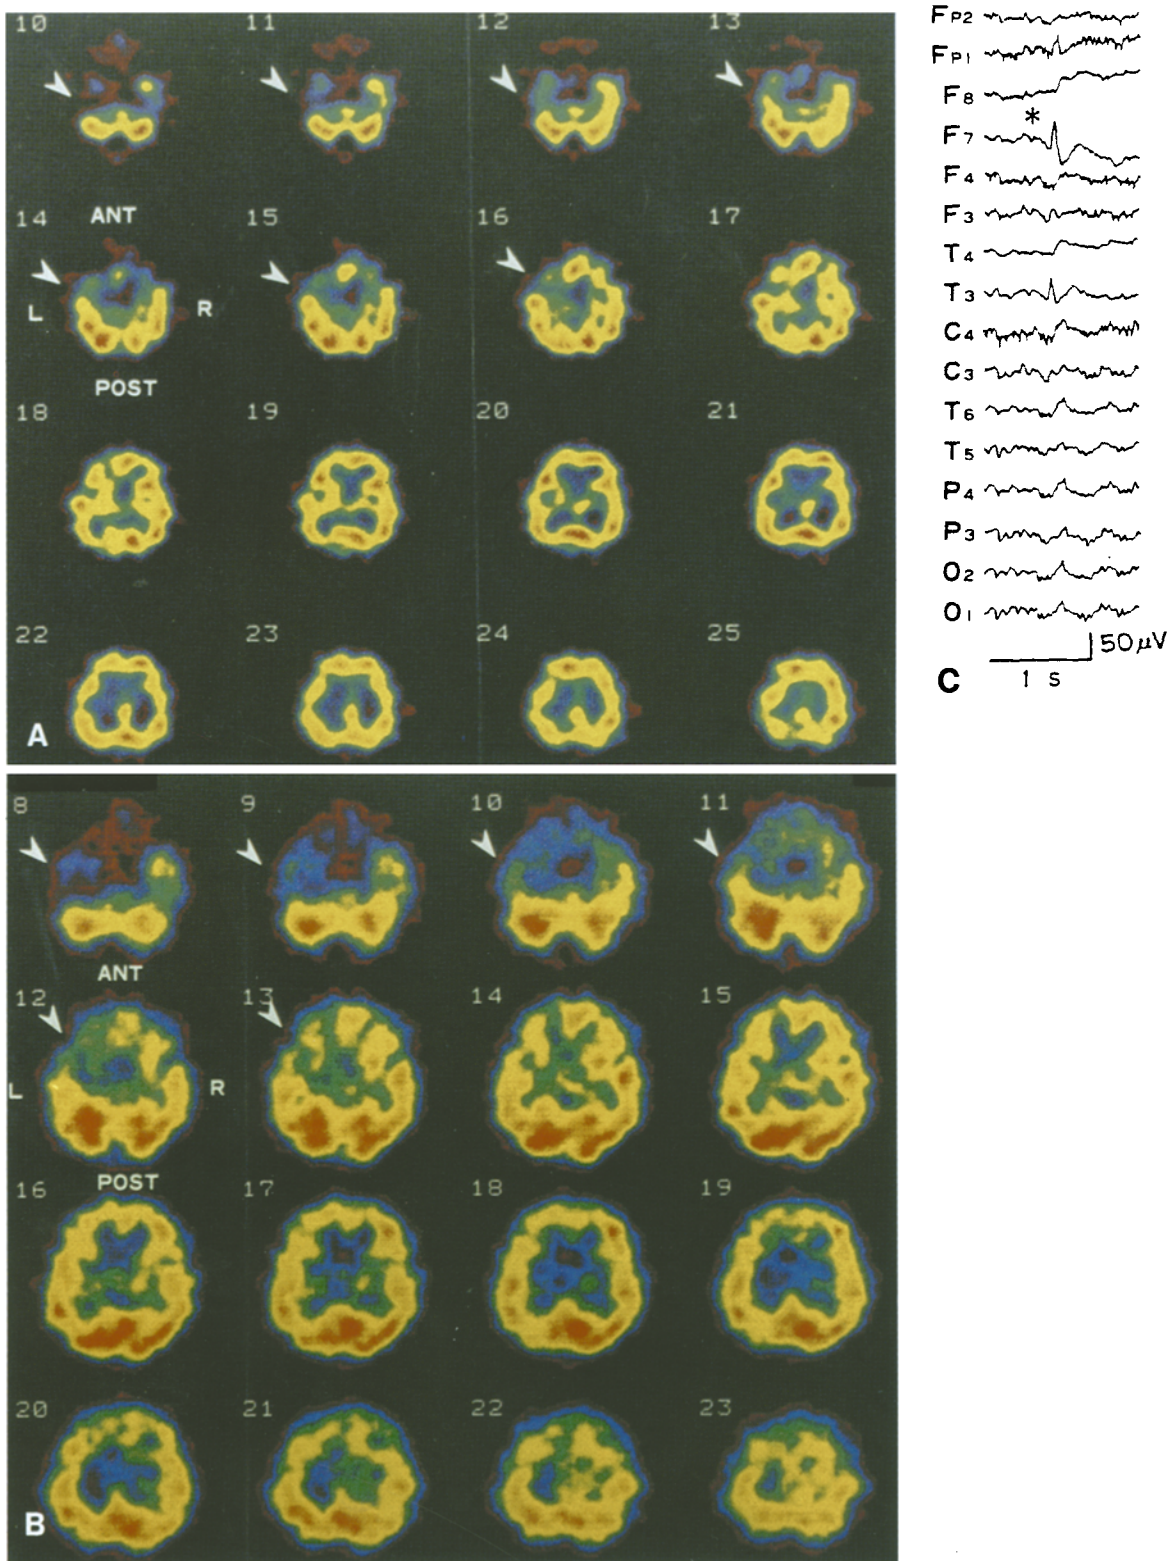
Good correspondence between regional SPECT abnormalities and epileptic EEG focus. Data from case 5 in Table 1 are presented. The upper and lower SPECTs indicate the first and second ones, respectively. *Arrows*, Hypofixation sites in the inferior part of the left temporal lobe; *, the epileptic discharge showing the EEG focus located in the anterior portion of the left temporal lobe. The numerals in SPECTs indicate the heights of slices sectioned every 6 mm from the orbitomeatal line towards the vertex
